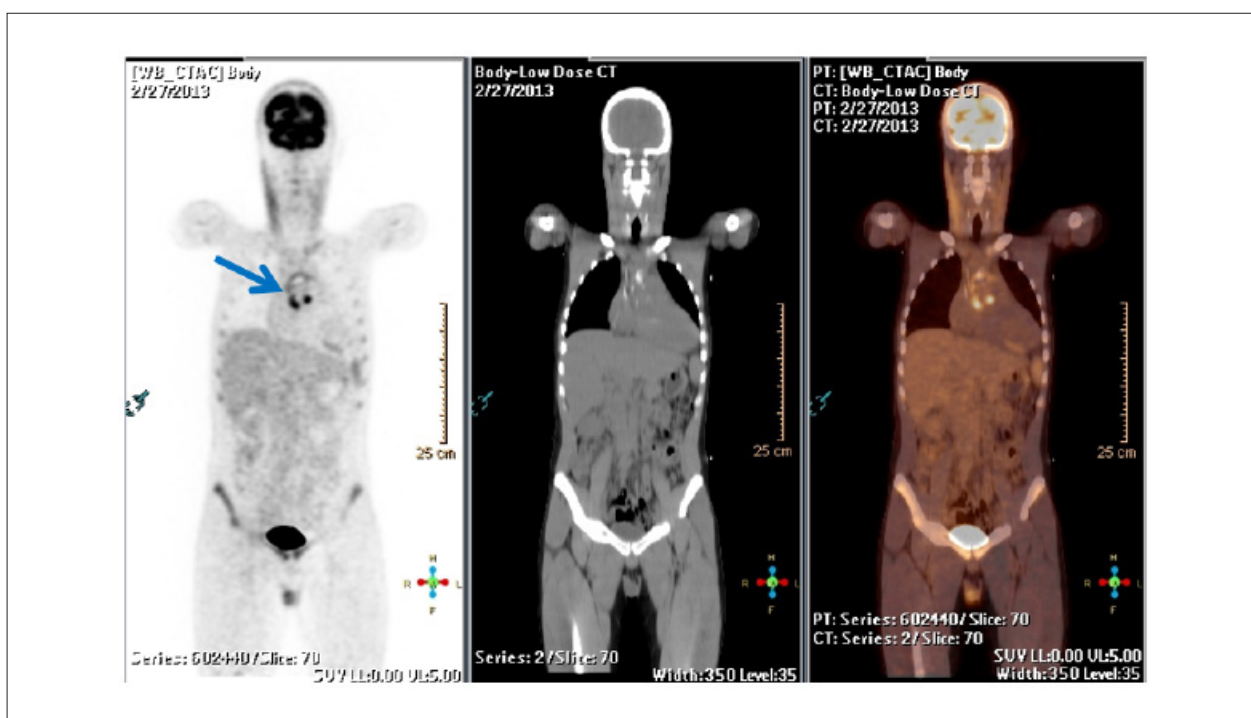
Male patient, age 19, with biological prosthesis in the aorta and mitral annuloplasty for 45 days. He evolved with fever, bacteremia, and blood culture positive for *S. Epidermidis*. FDG- ^{18}F - PET/CT study was positive for infection in the aortic prosthesis; maximum standard uptake value (SUV) = 9.7. Source: INCOR, FMUSP, SP.
